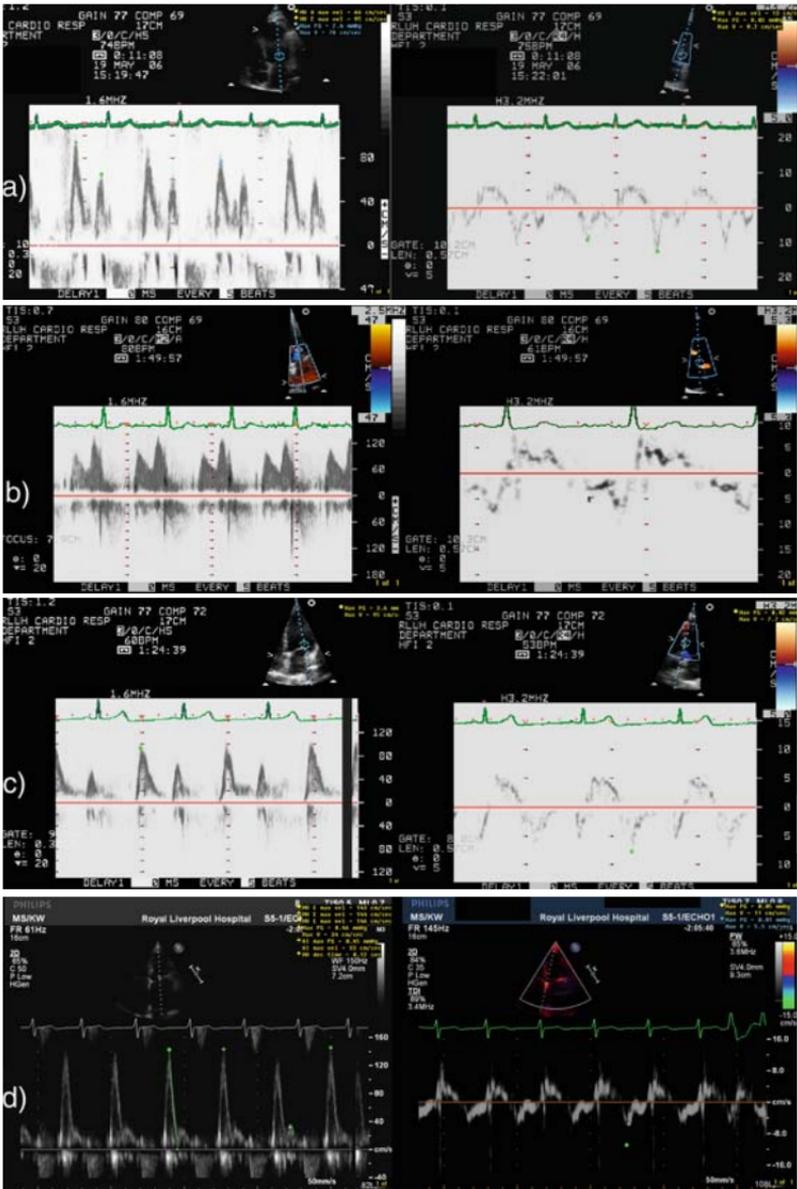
Flow and tissue Doppler imaging in the assessment of diastolic function. a Normal subject: $E/A = 1.43$, $E' = 13$ cm/s, $E/E' = 7.3$. b Elderly patient with mild (grade 1) diastolic dysfunction: $E/A = 0.8$, $E' = 3$. c Hypertensive patient with exertional dyspnea, normal coronary arteries, and $LVEDP = 17$ mm at catheterization. Echocardiography shows moderate (grade 2) diastolic dysfunction consistent with elevated diastolic pressures: $E = 95$ cm/s, $E' = 7.7$ cm/s, $E/E' = 12$. d Patient with severely decreased systolic function and dyspnea at rest. Echocardiography shows severe, restrictive (grade 3) diastolic dysfunction: $E/A = 4.6$, $DT = 120$ ms, $E' = 5.5$, $E/E' = 26$.
